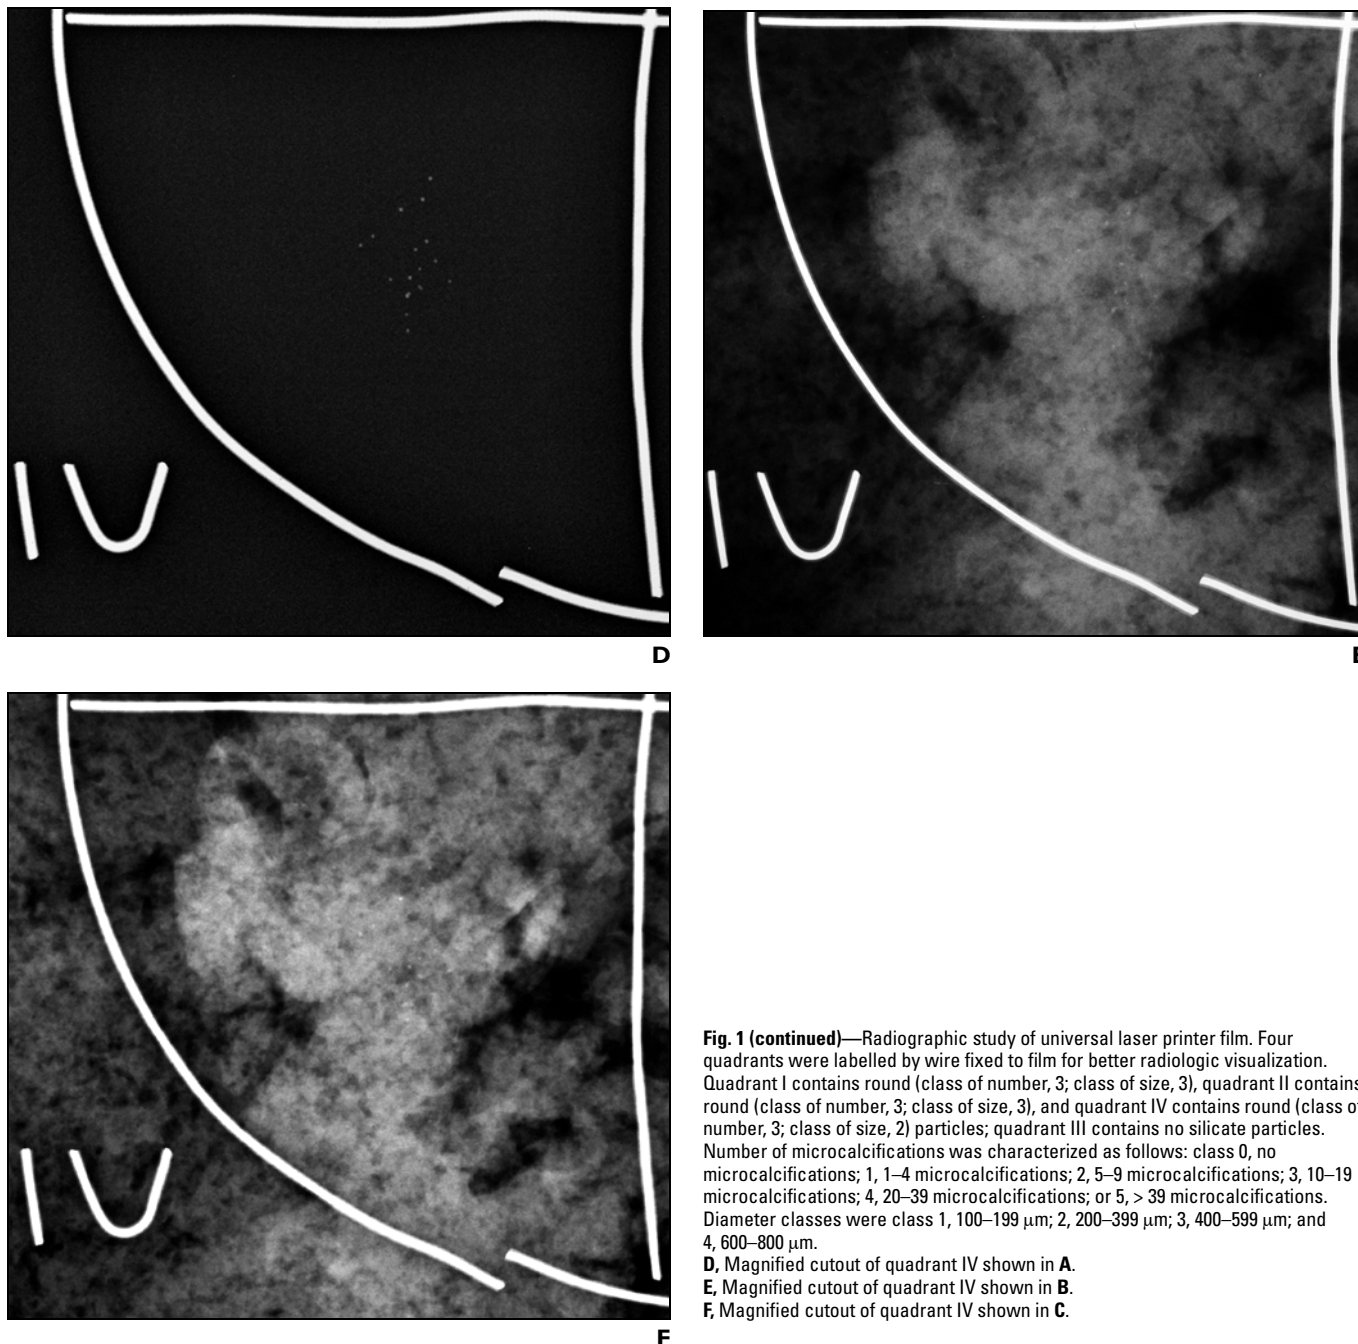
(continued)—Radiographic study of universal laser printer film. Four quadrants were labelled by wire fixed to film for better radiologic visualization. Quadrant I contains round (class of number, 3; class of size, 3), quadrant II contains round (class of number, 3; class of size, 3), and quadrant IV contains round (class of number, 3; class of size, 2) particles; quadrant III contains no silicate particles. Number of microcalcifications was characterized as follows: class 0, no microcalcifications; 1, 1–4 microcalcifications; 2, 5–9 microcalcifications; 3, 10–19 microcalcifications; 4, 20–39 microcalcifications; or 5, > 39 microcalcifications. Diameter classes were class 1, 100–199 μm ; 2, 200–399 μm ; 3, 400–599 μm ; and 4, 600–800 μm .
